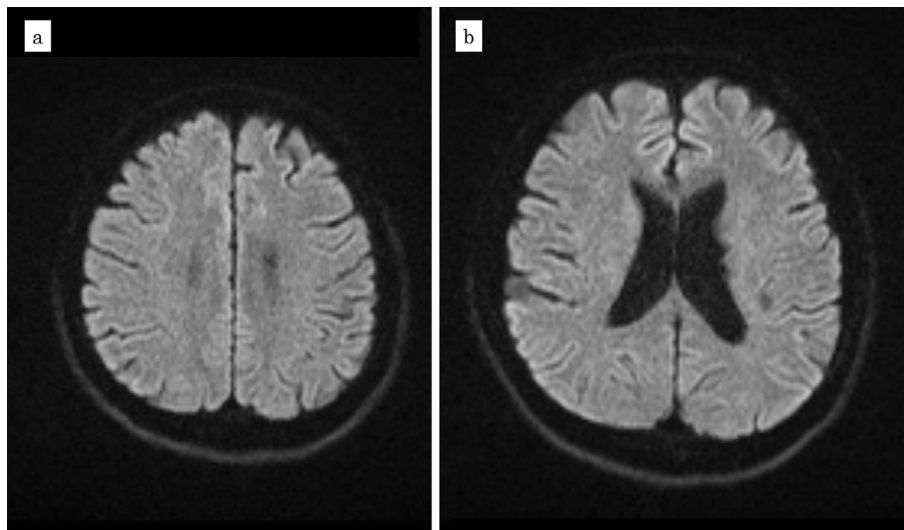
Head magnetic resonance imaging (MRI) of the left semioval center (a) and bilateral corona radiata (b), which was performed at 9 months after the onset of cerebral infarction. The high-intensity areas disappeared, and no new lesions were observed.
